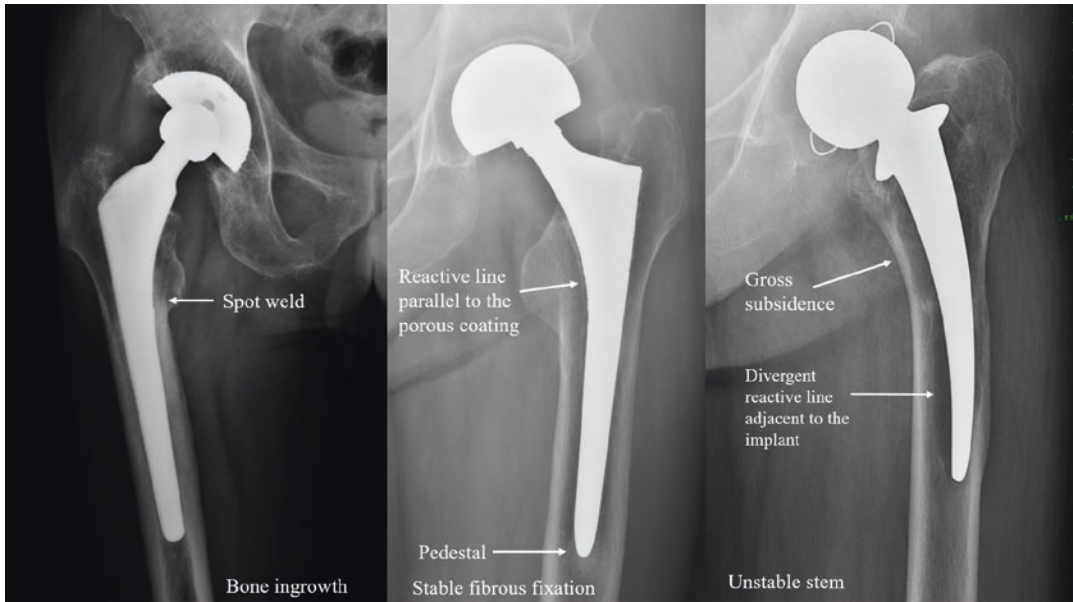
Radiographic assessment of cementless stem stability
